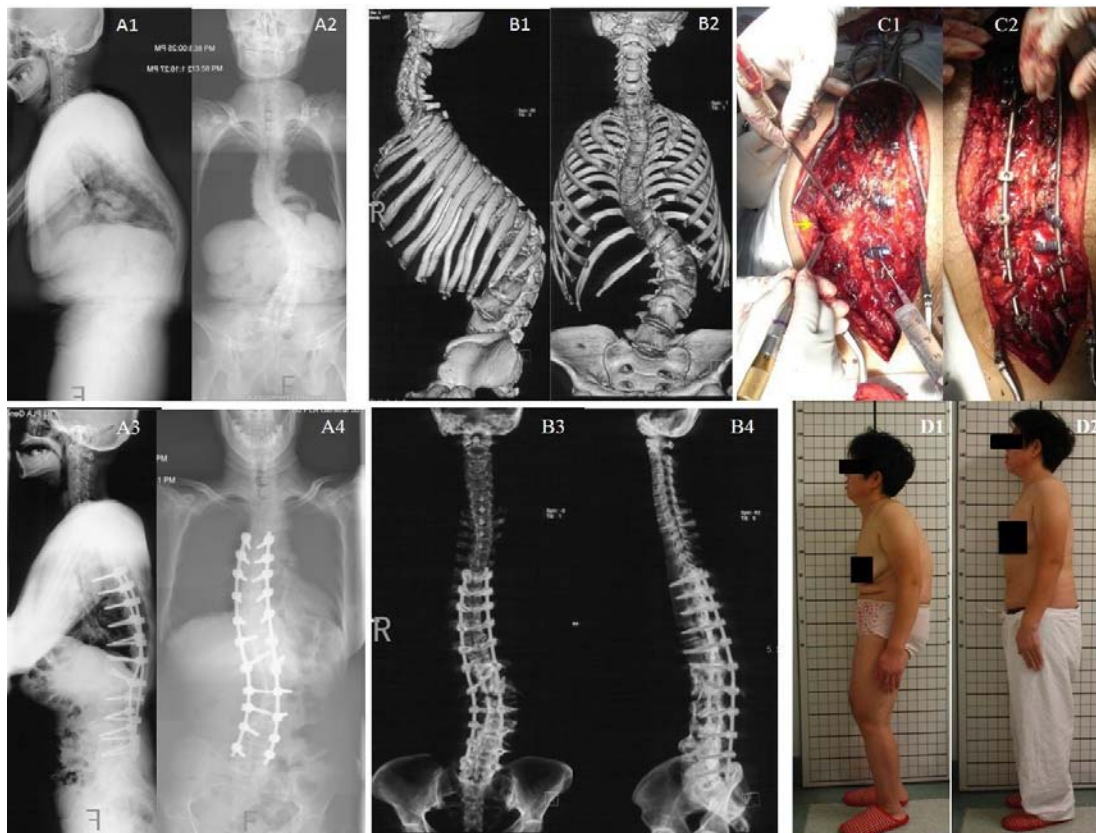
(A1-2) Standing lateral and anteroposterior radiographs of a 49-year-old female with a deformity of AS. (A3-4) The patient underwent L1 VCD osteotomy. (B1-2) anteroposterior and lateral CT scans show the thoracolumbar deformities both in the sagittal and coronal planes. (B3-4) Sagittal and coronal balances were both restored. (C1-2) The approach of this VCD osteotomy was not a transpedicular resection but a transvertebral procedure, which has the advantage of obtaining a multidimensional correction (yellow arrow indicates the transvertebral site). (D1) Preoperative lateral view. (D2) Postoperative lateral view shows the correction of the deformity with VCD osteotomy at L1
